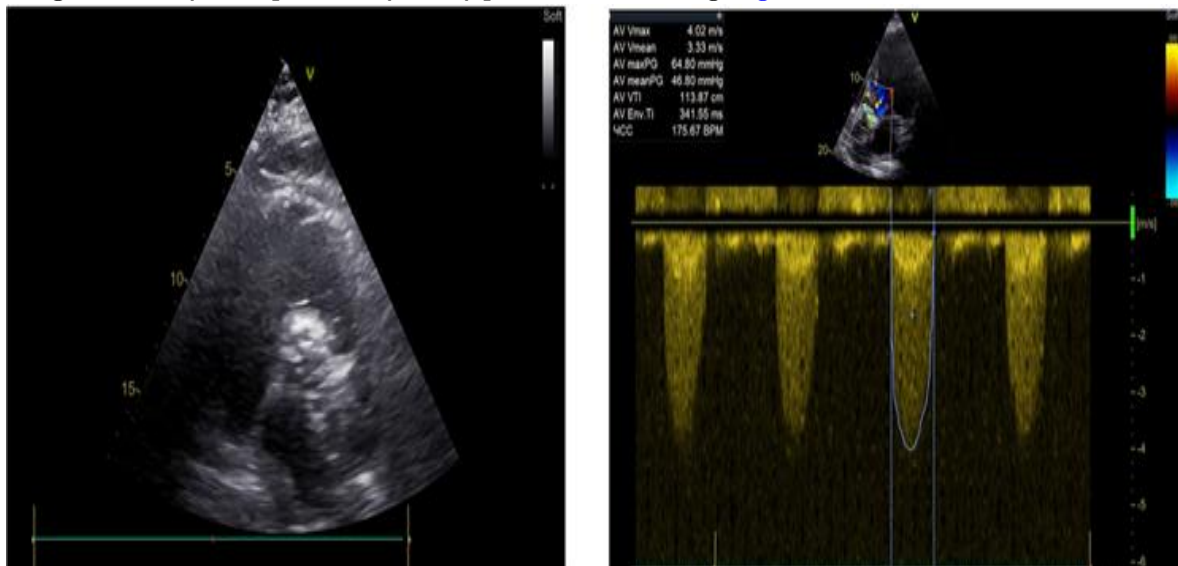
Preoperative transthoracic EchoCG. In the projection of the aortic valve, severe calcinosis of the annulus and leaflets is visualized.
